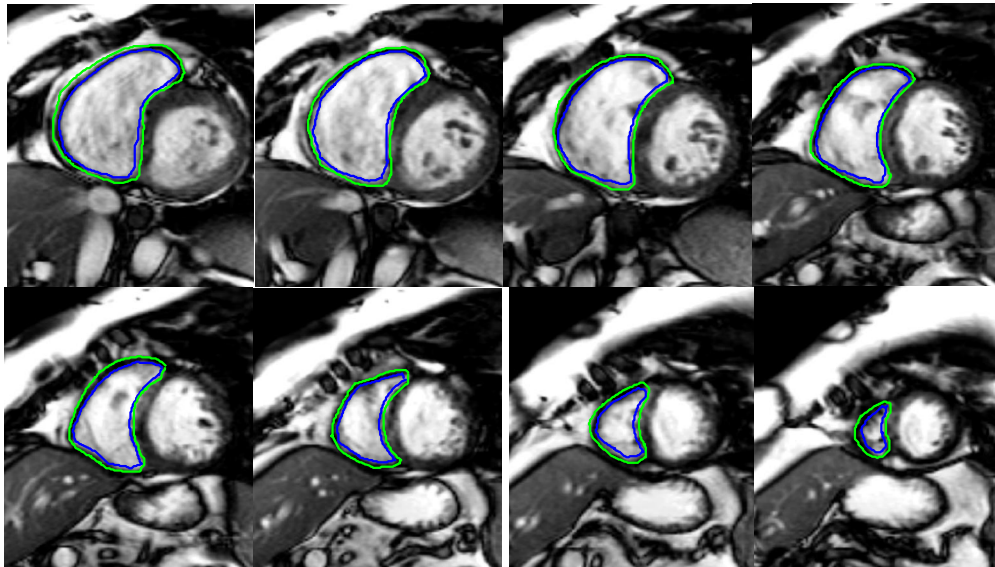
SAV MRI from RVSCD at the end diastolic cardiac phase for a patient with no cardiac abnormalities with segmentation performed on right ventricle endocardium (blue contours) from the base slice (upper left image) to apex slice (lower right image)
